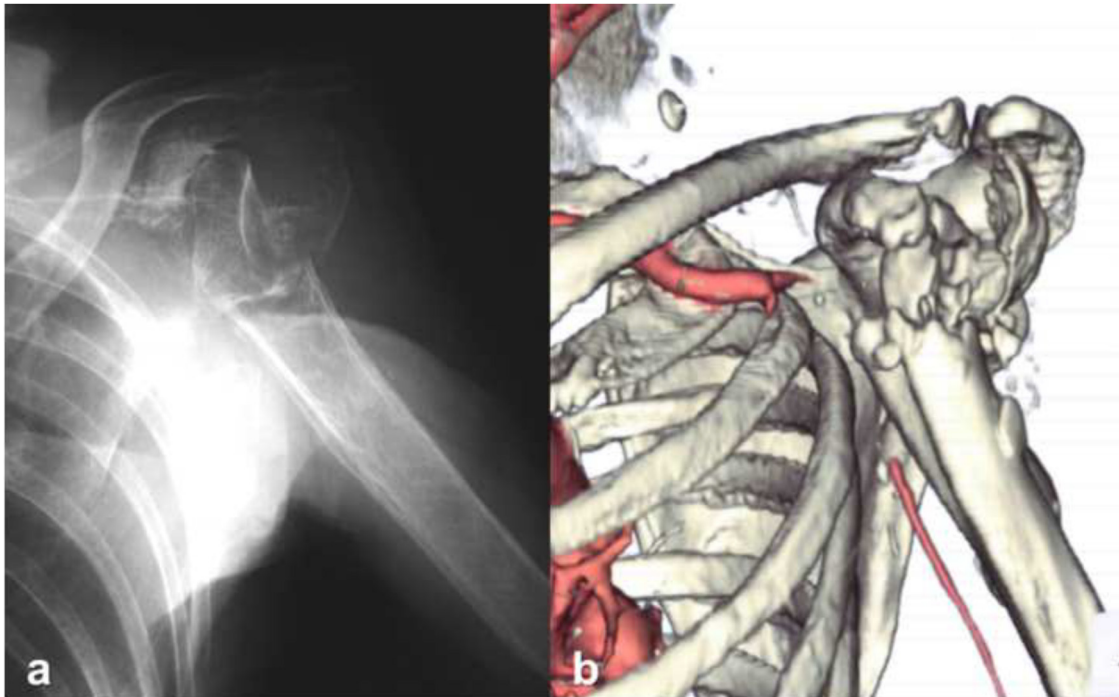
Case 1. An 88-year-old woman who had a large hematoma on the anterior part of the left shoulder. The proximal humeral fracture was severely displaced (a). CT angiography revealed disruption of the axillary artery blood flow at the level of distal of thoracoacromial artery (b).
